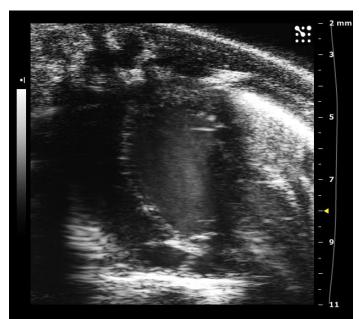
B-Mode Apical 4 Chamber image displaying the apex at the top of the image, the left and partial right ventricles and mitral and tricuspid valves.
